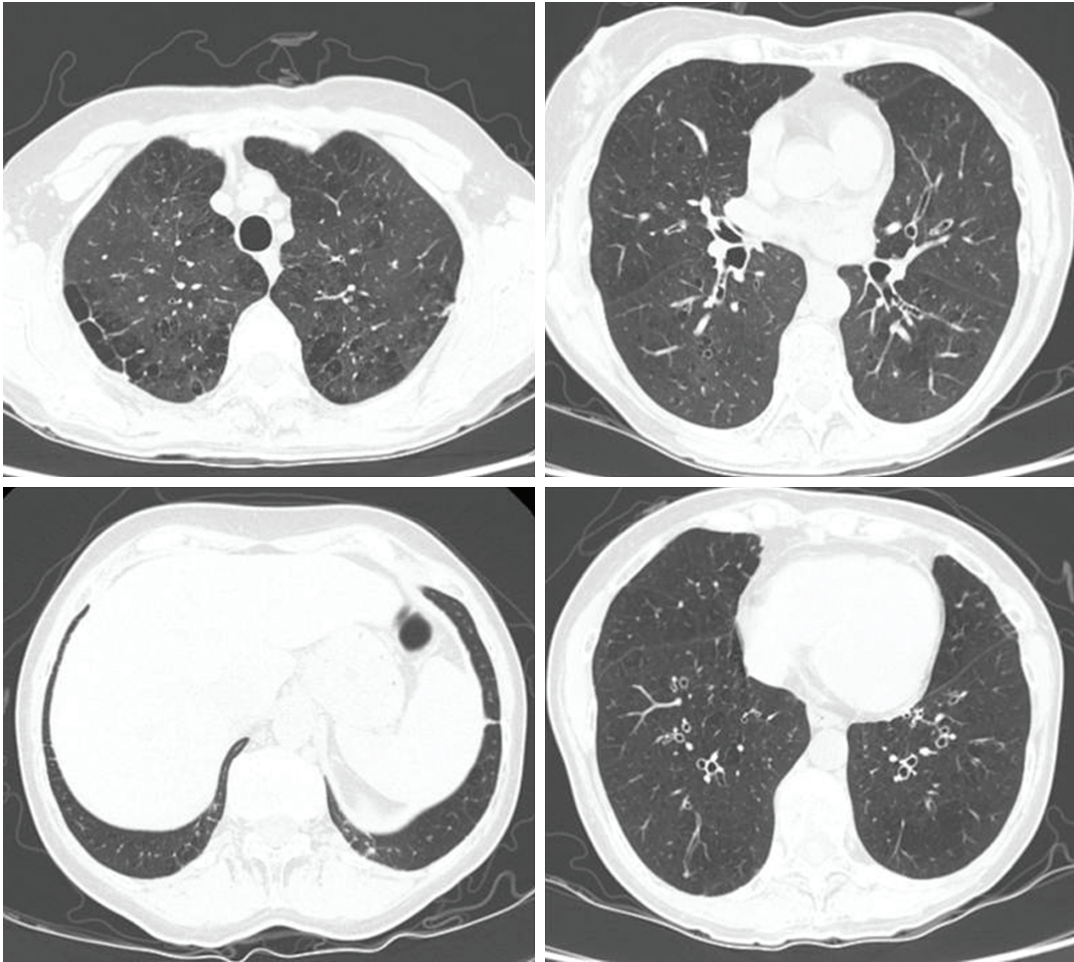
HRCT scan showing centrilobular and paraseptal emphysema, cylindrical bronchiectasis, and two micronodules (one in the left lower lobe and the other in the right lower lobe).
